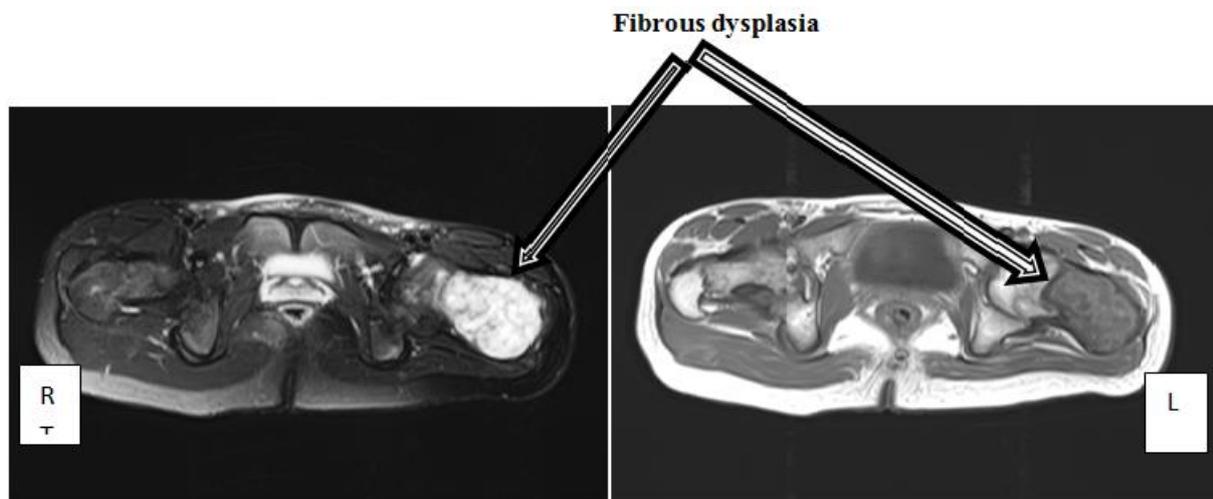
MRI axial T2 image have a higher intensity signal shows a heterogeneous high signal within a fibrous dysplasia in the proximal shaft of the left upper femur. (arrow)
